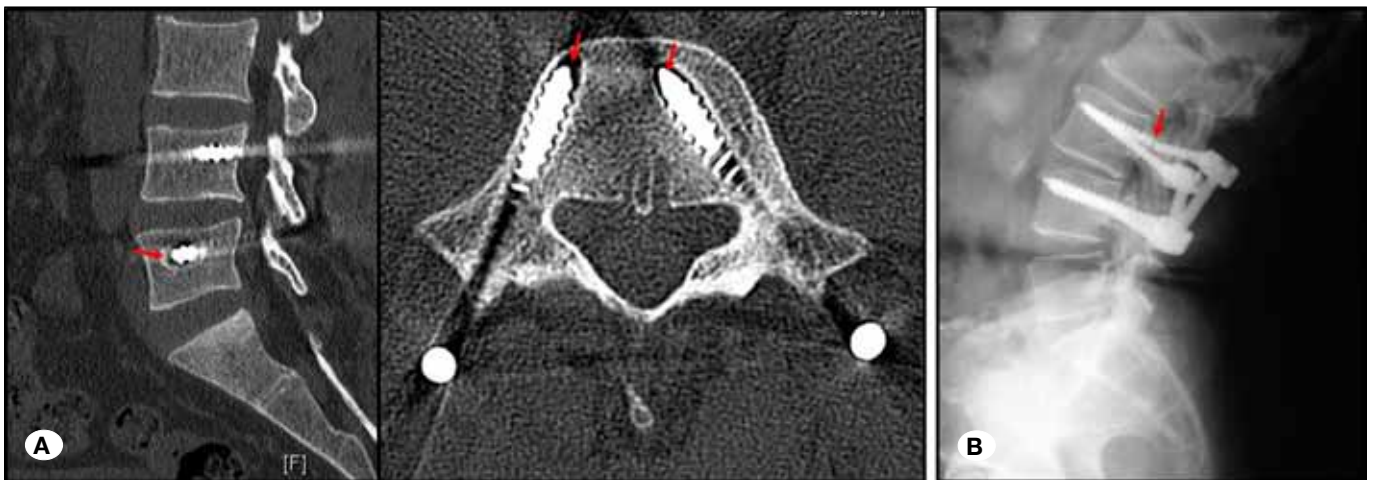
A) CT scan shows bilateral L5 screw loosening; radiolucent area around the screw depicts loosening (red arrow); B) X-ray shows screw fracture at the L3 vertebra.
